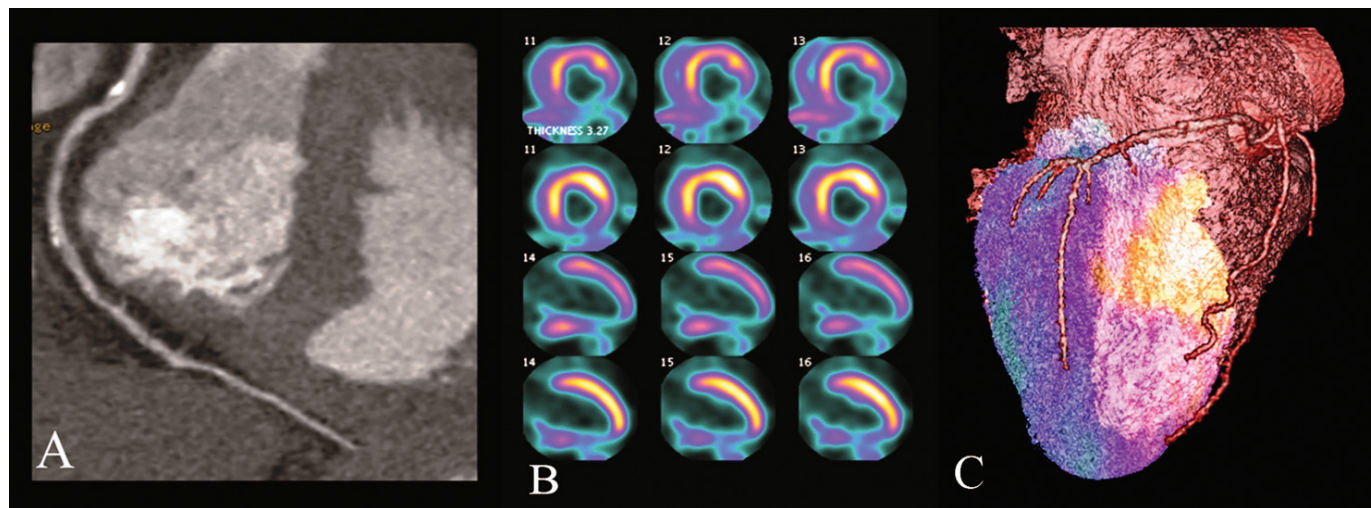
Dual-source computed tomography image showing significant stenosis in the proximal right coronary artery (RCA) (A), positron emission tomography images showing an inferior perfusion defect in the distal RCA (B), and fusion images showing that the lesion in the RCA is causing the inferior perfusion defect (C).
